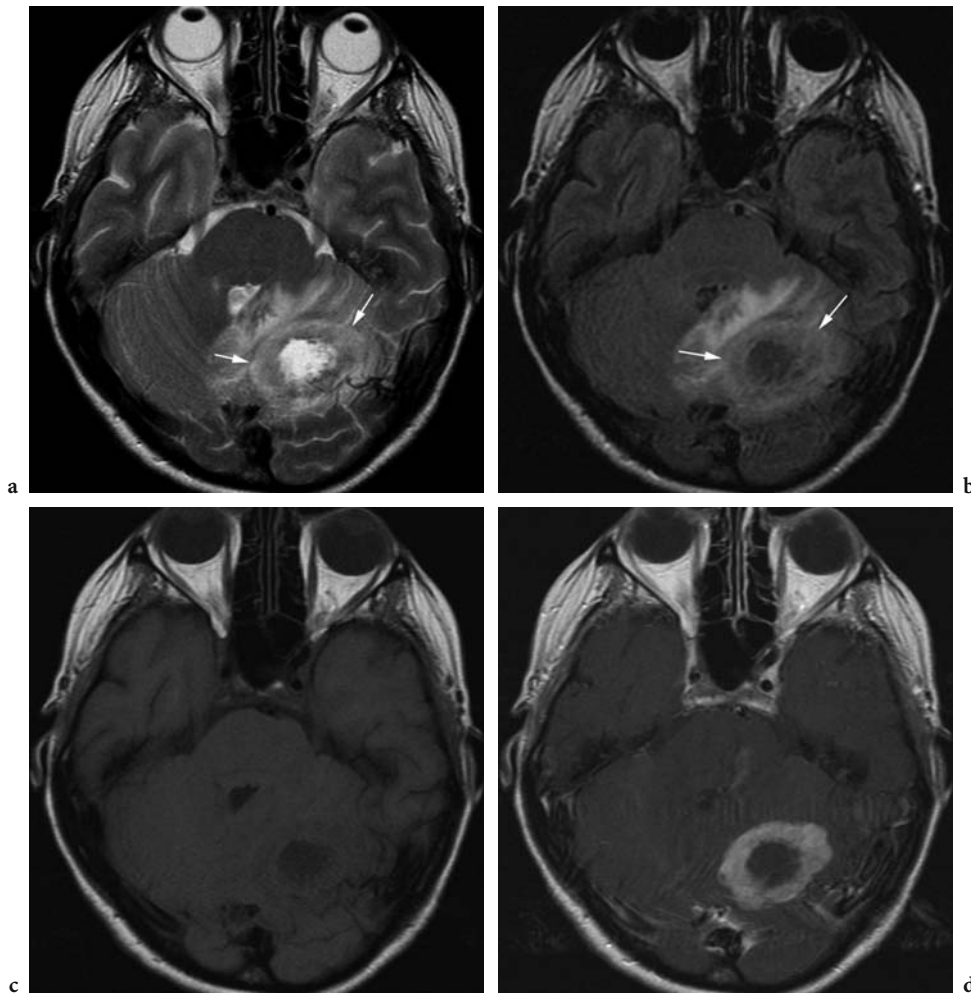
Unique cerebellar metastasis in a 46-year-old woman treated for renal cell carcinoma. Axial a T2-weighted and b fluid-attenuated inversion recovery (FLAIR) MR images show a large left cerebellar lobe lesion which has a slightly hyperintense thick peripheral ring (*arrow*) and is surrounded by hyperintense vasogenic edema with mass effect on the fourth ventricle. The frank central hyperintensity on T2-weighted and hypointensity on FLAIR images corresponds to necrosis. c Axial unenhanced T1-weighted MR image shows that the ring and edema are difficult to discern. Only the hypointense necrosis and mass effect on the fourth ventricle are obvious. d Axial contrast-enhanced T1-weighted MR image demonstrates a characteristic strong ring enhancement of the lesion. (Image courtesy of F. Lafitte)
